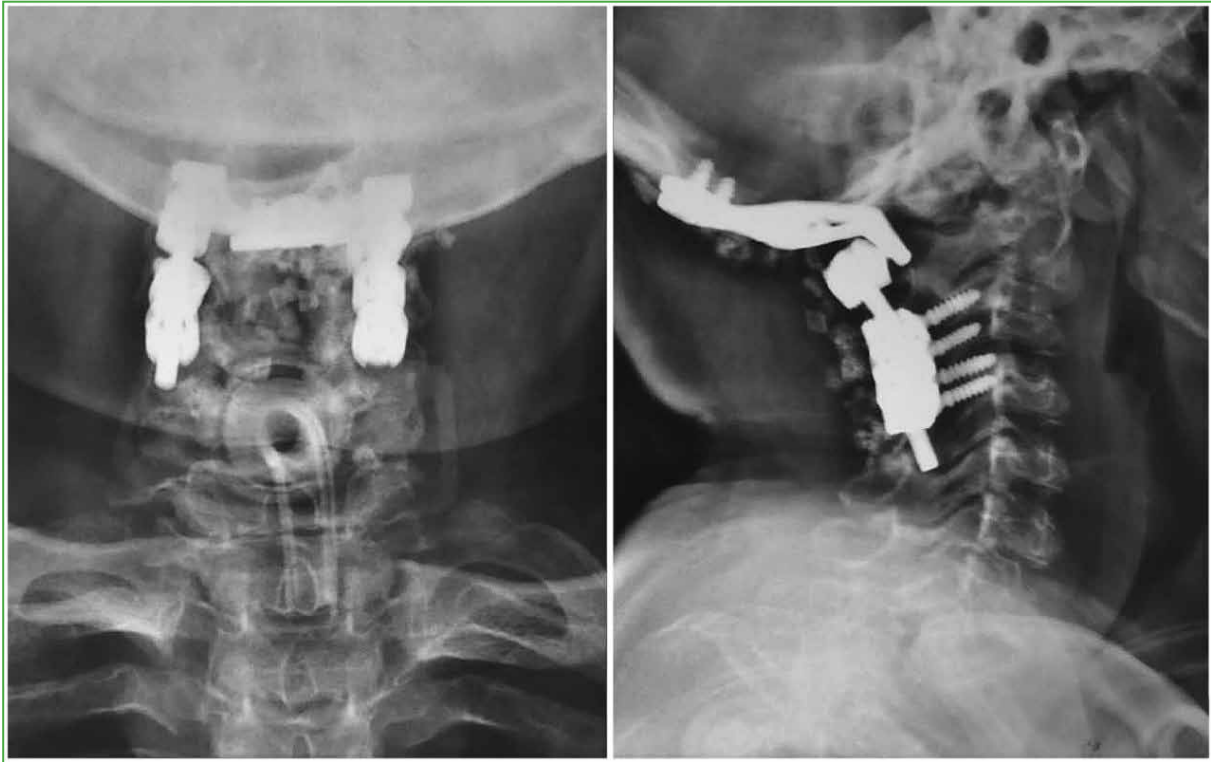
Anteroposterior and lateral cervical radiographs, after 9 months. Occipito-cervical instruments (C0-4) without signs of loosening.
